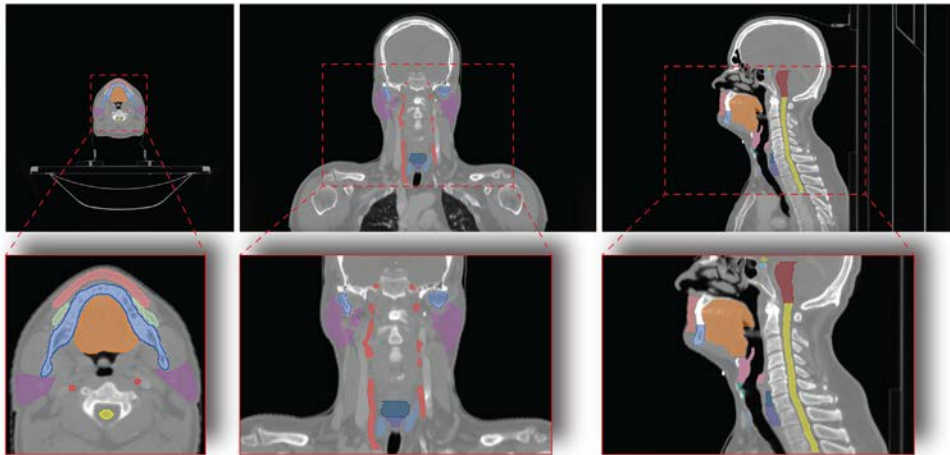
Example of reference organ-at-risk (OAR) segmentations for the computed tomography image from Figure 1, displayed in selected axial (*left*), coronal (*middle*), and sagittal (*right*) cross-sections as original images (*top row*), and enlarged regions of interest (*bottom row*). The OAR color-coded overlay corresponds to Figure 3.
